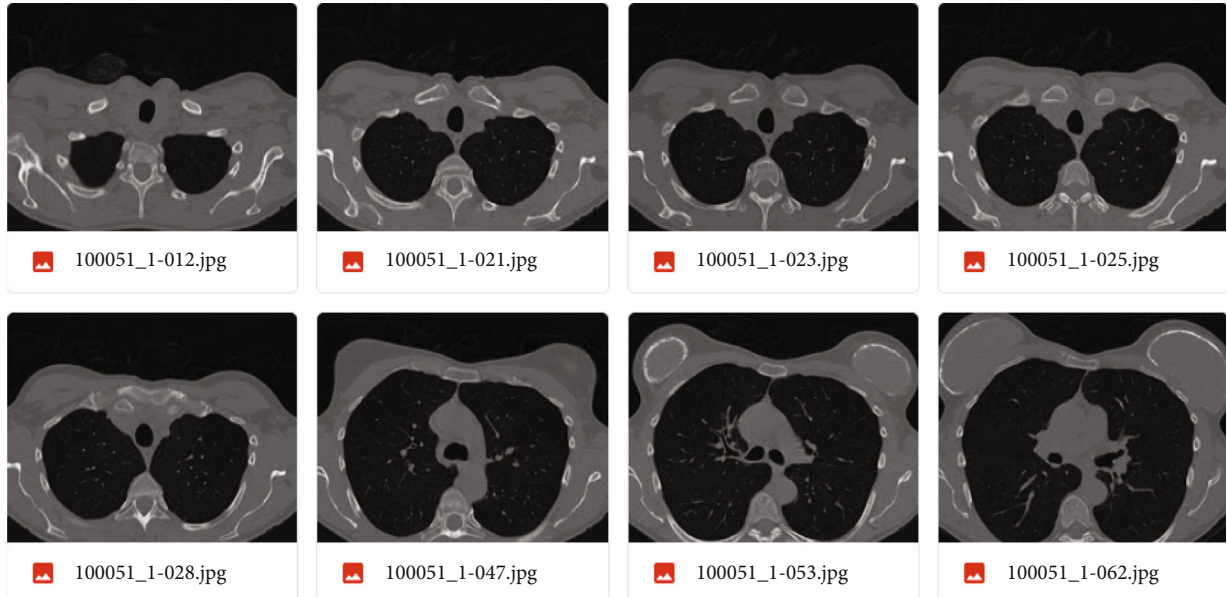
Sample CT images of the heart collected from clinical dataset.
